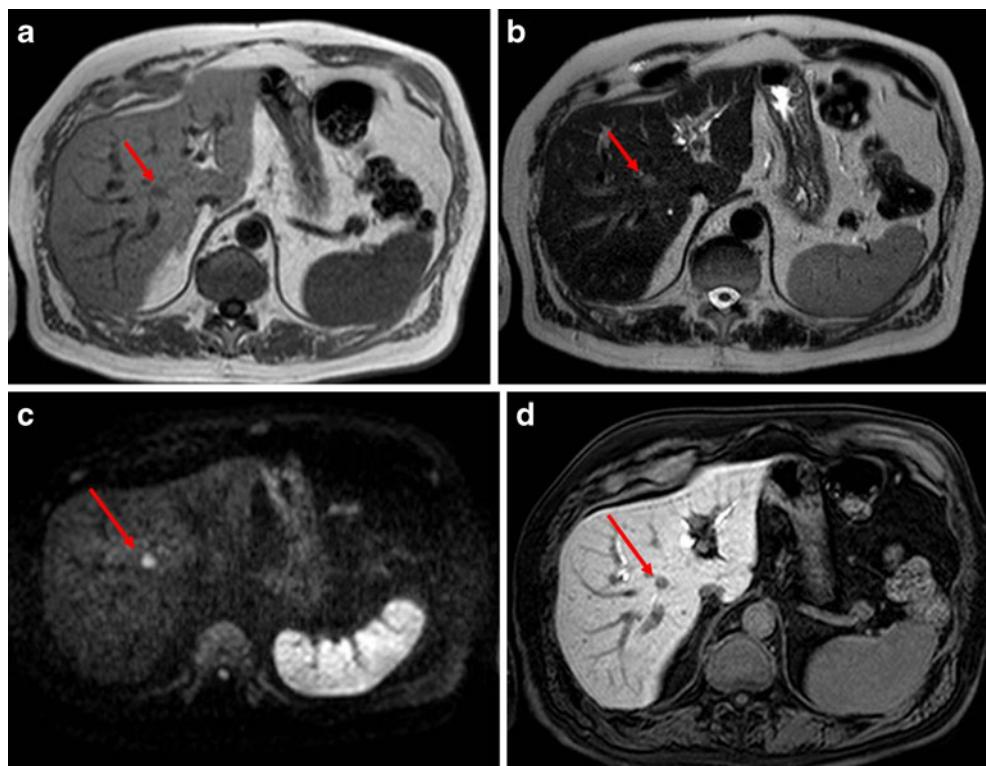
This is an example of how DWI with unenhanced images can be difficult to interpret. In this image DWI identifies an hyperintense area (c) not detected on T1-weighted and T2-weighted images. During the hepatospecific phase (d), it is clear that this area corresponds to a biliary structure
